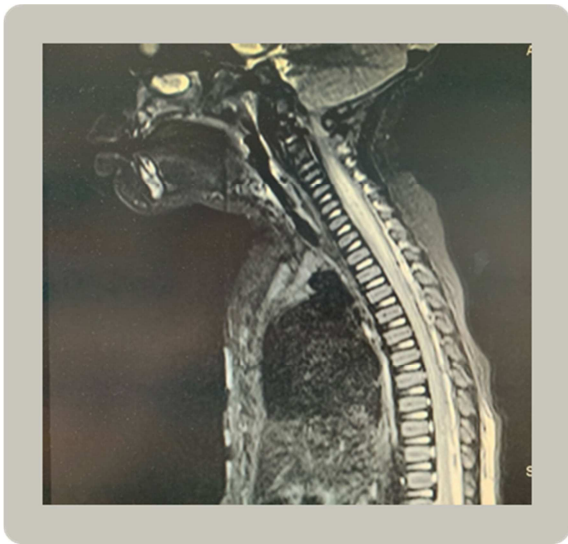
MRI scan revealing transverse myelitis.
